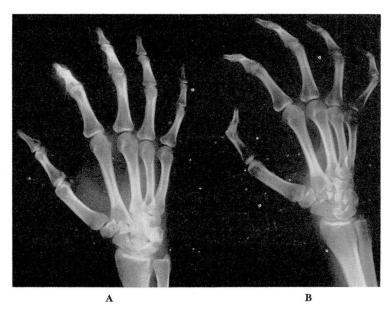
(A) Roentgenogram taken before the patient was given chloroquine phosphate therapy. (B) One year after beginning chloroquine phosphate therapy; note generalized demineralization of the bones in the hand and the wrist, and a cystic change in the navicular bone.
